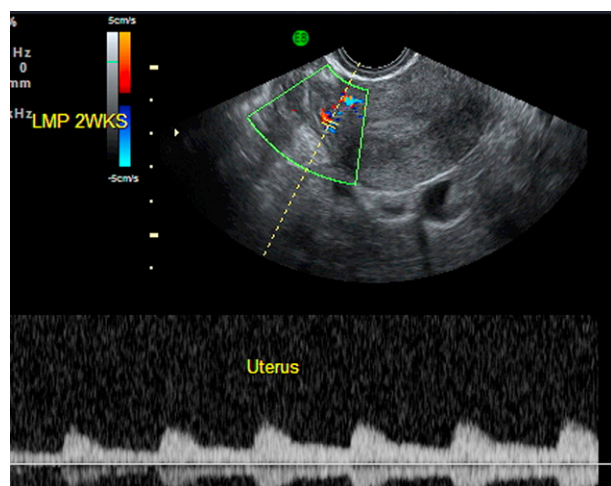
Doppler blood flow velocimetry of the uterine artery.
